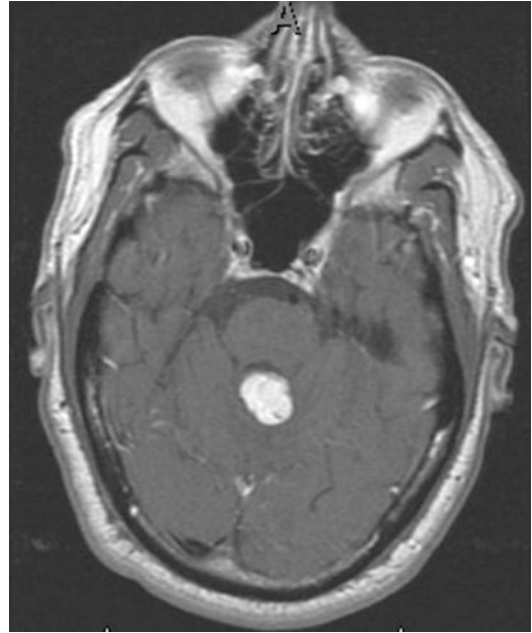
MRI scan of a patient with a hemangioblastoma in the midline involving the cerebellar vermis
